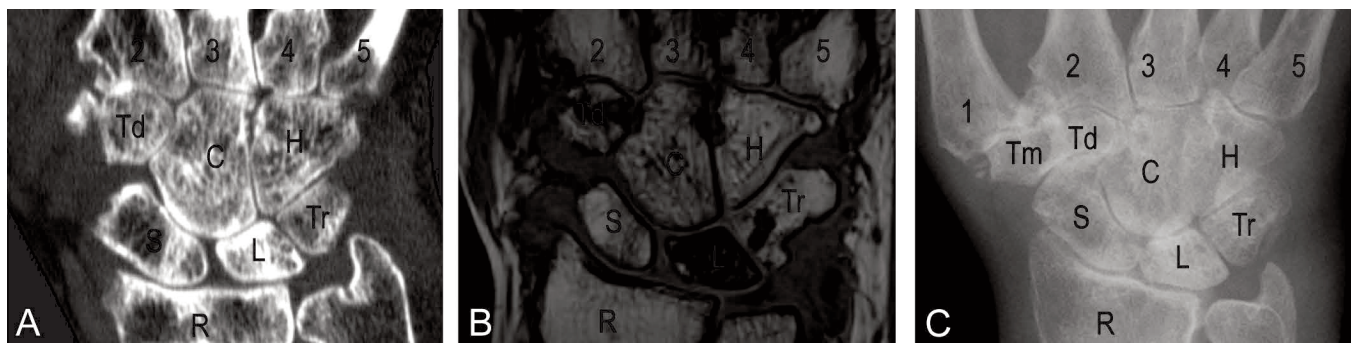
Computed tomography (CT; A), magnetic resonance imaging (MRI; B), and radiography (C) of the wrist of a patient with rheumatoid arthritis. A coronal CT slice, the corresponding coronal T1-weighted slice, and the conventional radiograph in posterior–anterior projection are shown (note that not all joint spaces are visible in this slice). CMC: carpometacarpal; Tm: trapezium; Td: trapezoid; C: capitate; H: hamate; S: scaphoid; L: lunate; Tr: triquetrum; R: radius. Joint space narrowing scores on CT/MRI were CMC1 = 3/3; CMC2 = 3/1; CMC3 = 2/0; CMC4 = 2/0; CMC5 = 1/0; Tm-Td = 3/1; Td-C = 3/1; C-H = 0/1; Tm-S = 2/3; Td-S = 0/1; C-S = 1/1; C-L = 2/0; H-T = 0/0; S-L = 0/0; L-T = 1/1; R-S = 1/1; R-L = 1/1. Sharp/van der Heijde joint space narrowing scores were CMC3 = 2; CMC4 = 2; CMC5 = 0; Tm/Td-S = 2; C-S = 3; R-S = 2.
